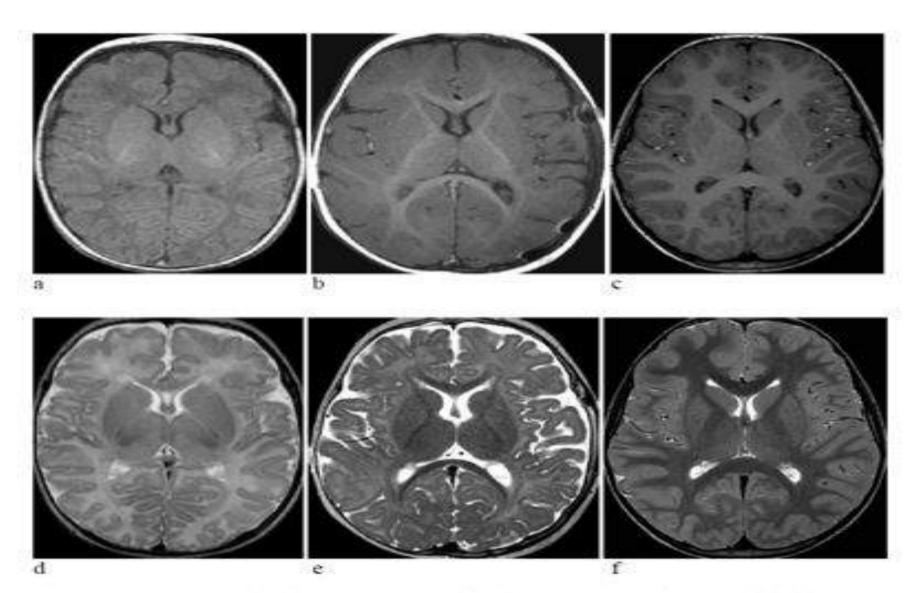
Progress of myelination on T1-weighted (upper row) and T2-weighted (lower row)
